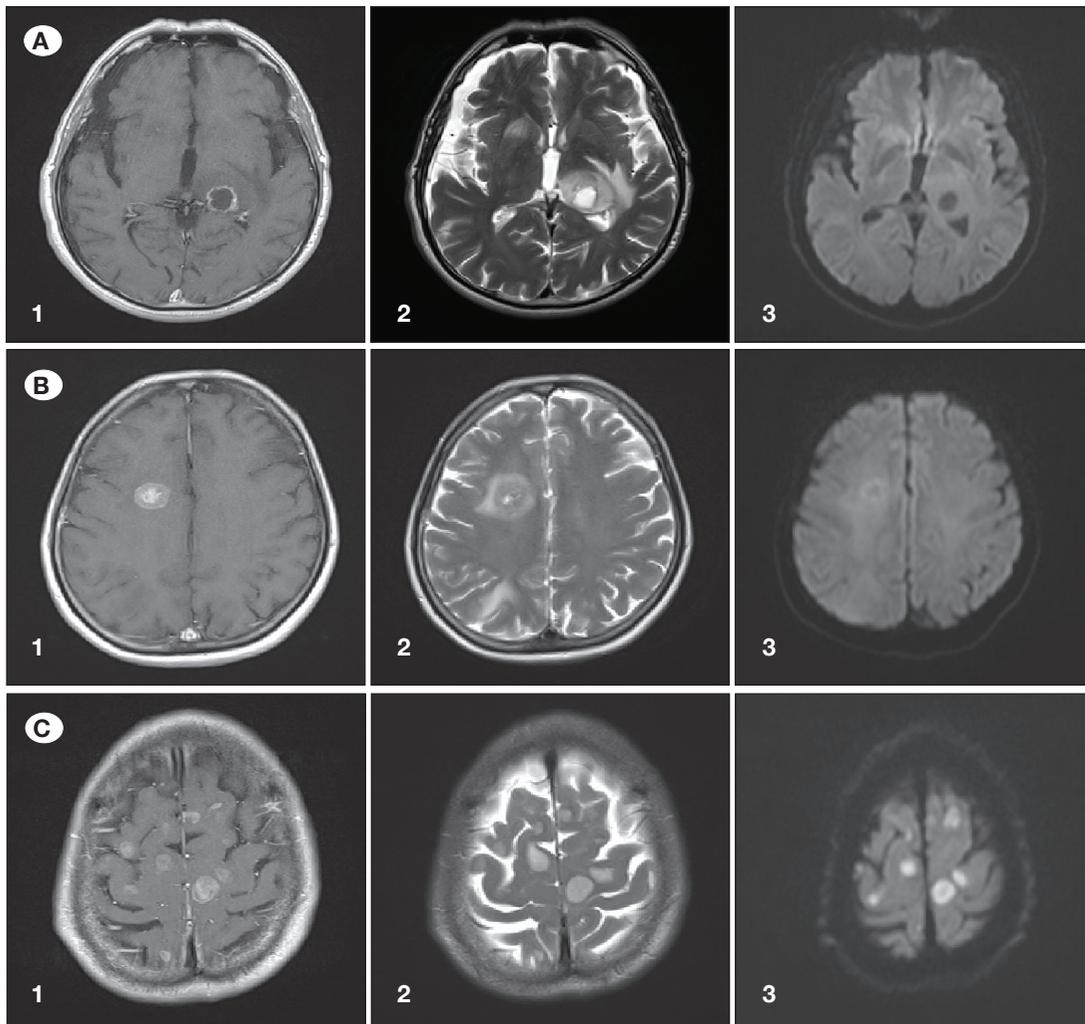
Representative MR images that demonstrate visual scores on the basis of DWI results attained for brain metastases of NSCLC (A1, A2, A3), breast carcinoma (B1, B2, B3), and SCLC (C1, C2, C3). Contrast-enhanced T1 weighted images show enhanced tumour in the left thalamus (A1), right frontal lobe (B1), and left frontal lobe (C1). T2 weighted images show peritumoral brain oedema if present (A2,B2,C2). Brain metastases are not detectable on DWI in type 1 (A3). DWI images show iso-signal intensity in type 2 (B3) and high signal intensity in type 3 (C3) respectively, relative to normal-appearing cortical grey matter.
